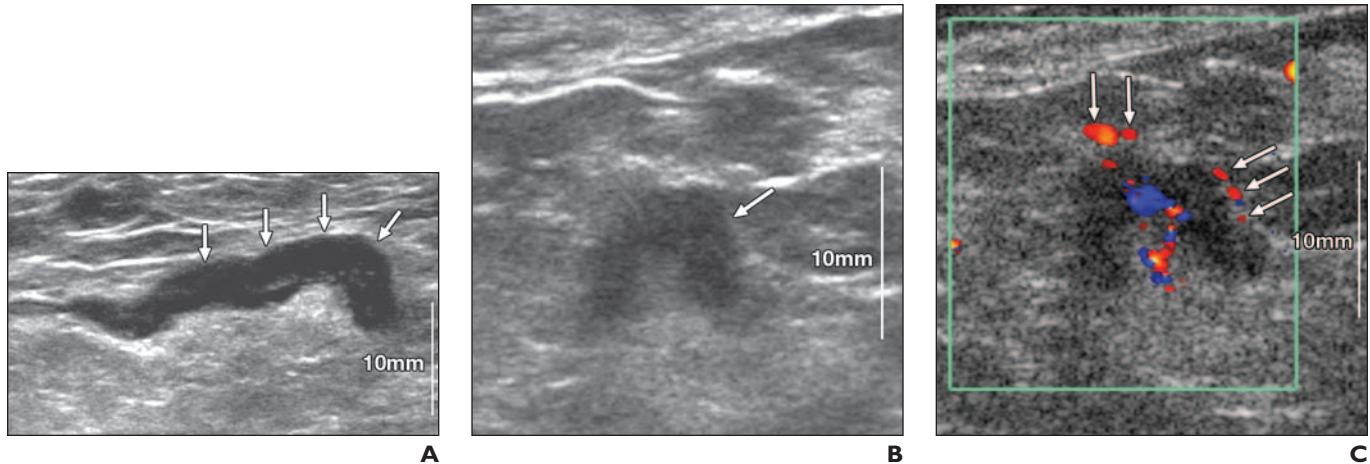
Ultrasound of metastatic axillary lymph node in patients with invasive carcinoma.
